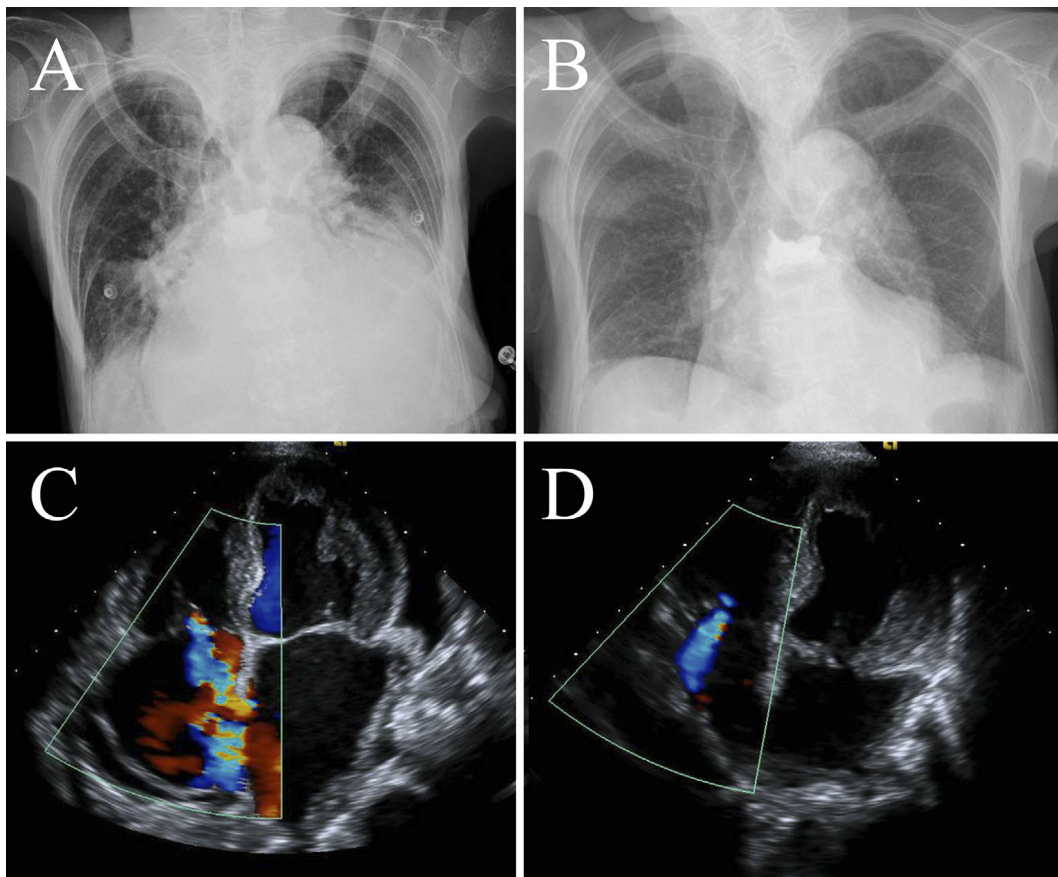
The cardiomegaly and pulmonary congestion of the chest X-ray improved before (A) and after the procedure (B). (C) Echocardiography showed right heart dilatation, pericardial effusion, and severe tricuspid regurgitation before the procedure. (D) After the procedure, the tricuspid regurgitation improved.
